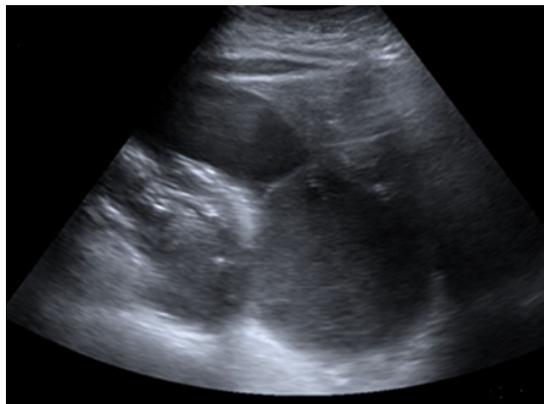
Ultrasonography of upper and lower abdomen.
